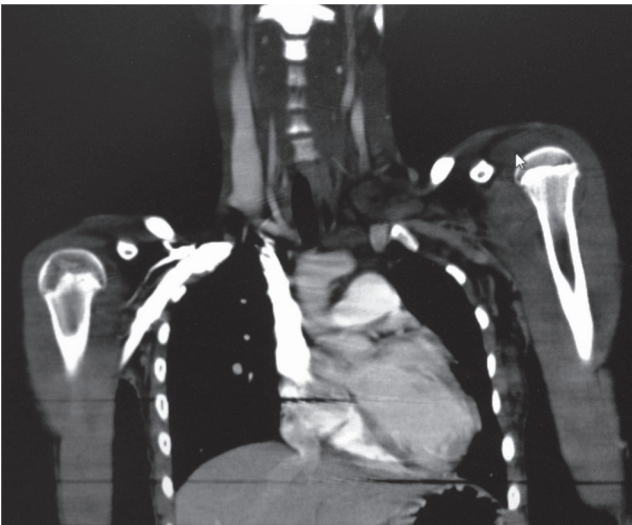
Enhanced computed tomography showed that the right subclavian vein and cephalic vein were large enough (2006.12.11) for lead insertion. The right external and internal jugular veins are identical.
